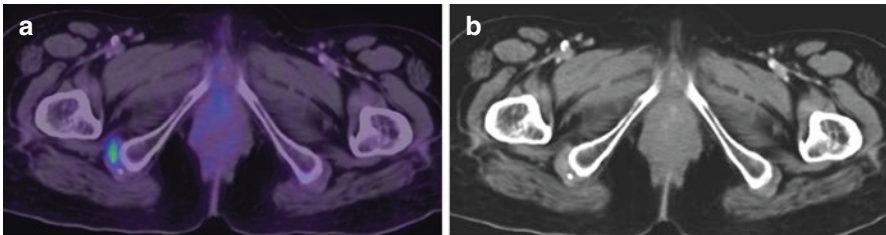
Mild focal FDG uptake at the site of muscle attachment in the right ischium due to enthesitis
